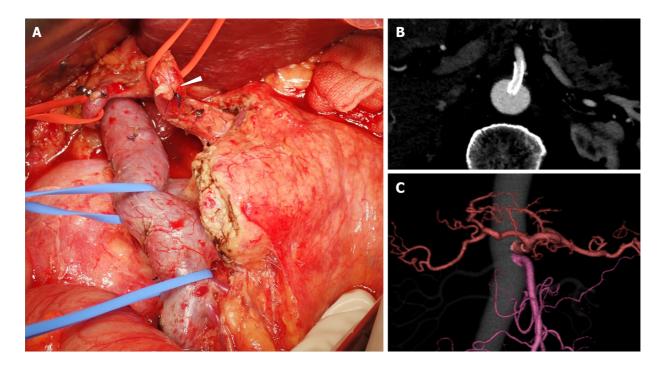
Intraoperative view and postoperative computed tomography images. A: Subtotal stomach preserving pancreaticoduodenectomy was performed. White arrowhead: stump of gastroduodenal artery; B and C: Postoperative computed tomography imaging confirmed patency of the celiac axis.
